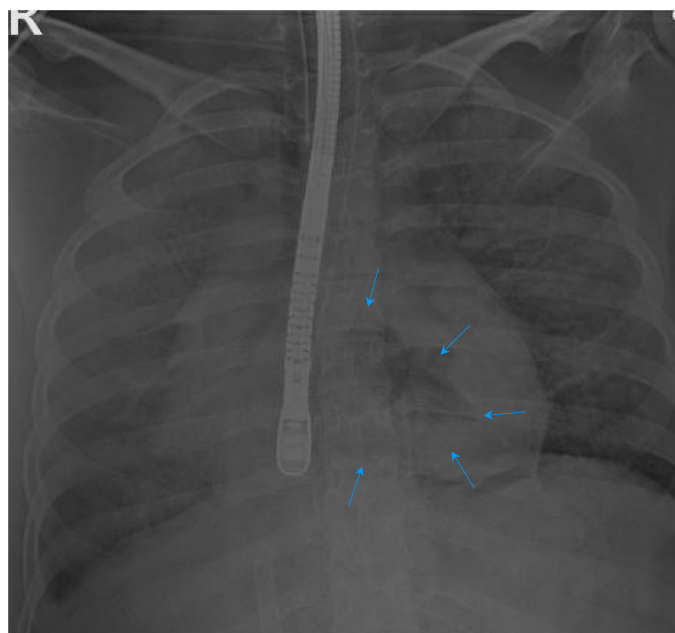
Air embolism in cardiac chamber (arrow) confirmed with chest X-ray taken at the operating room.
